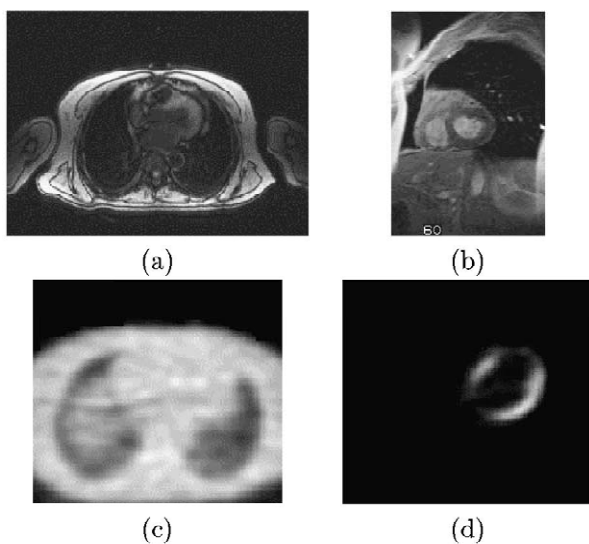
(a) Transaxial and (b) SA MR images, (c) transmission and (d) emission PET images.
